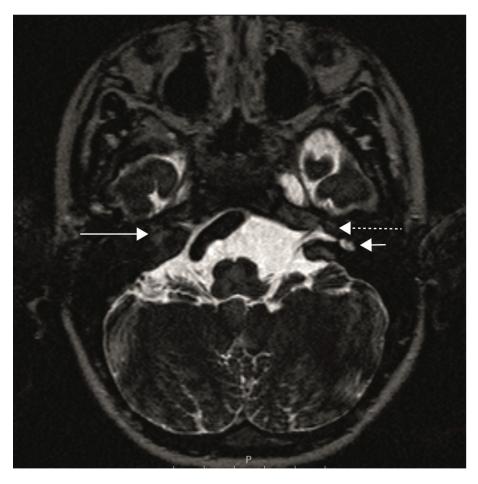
MRI of the temporal bone (axial plane), CISS sequences (constructive interference in steady state) with a right cochlear aplasia (long solid arrow), aplasia of the right inner ear canal, left cochlear aplasia (long dashed arrow) and dysplastic left vestibule (short arrow).
